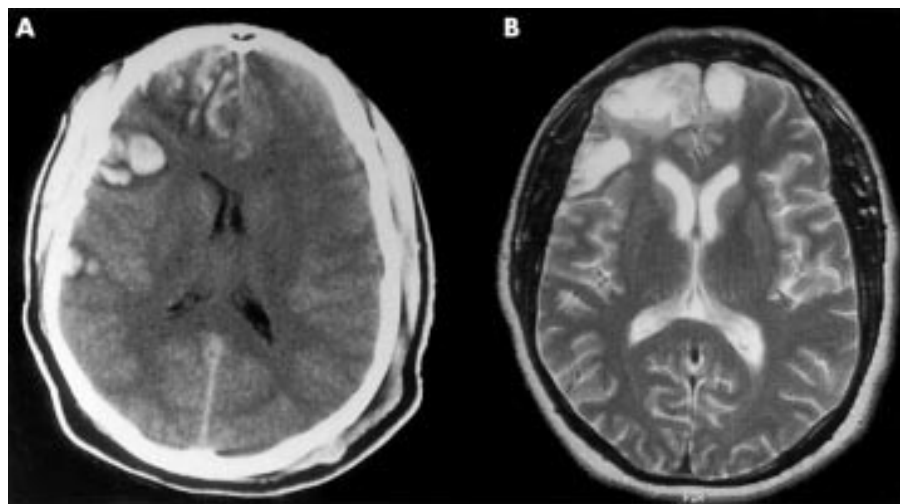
Thirty six year old man: assault. (A) Computed tomography (CT) acutely shows superficial haemorrhagic frontotemporal contusion, mainly on the right with some involvement of the medial aspect of the left frontal lobe, and mass effect with distortion of the anterior horn of the right lateral ventricle. (B) Subsequent T2 weighted magnetic resonance imaging (MRI) shows cystic encephalomalacia and gliosis at the sites of the previous contusions.
